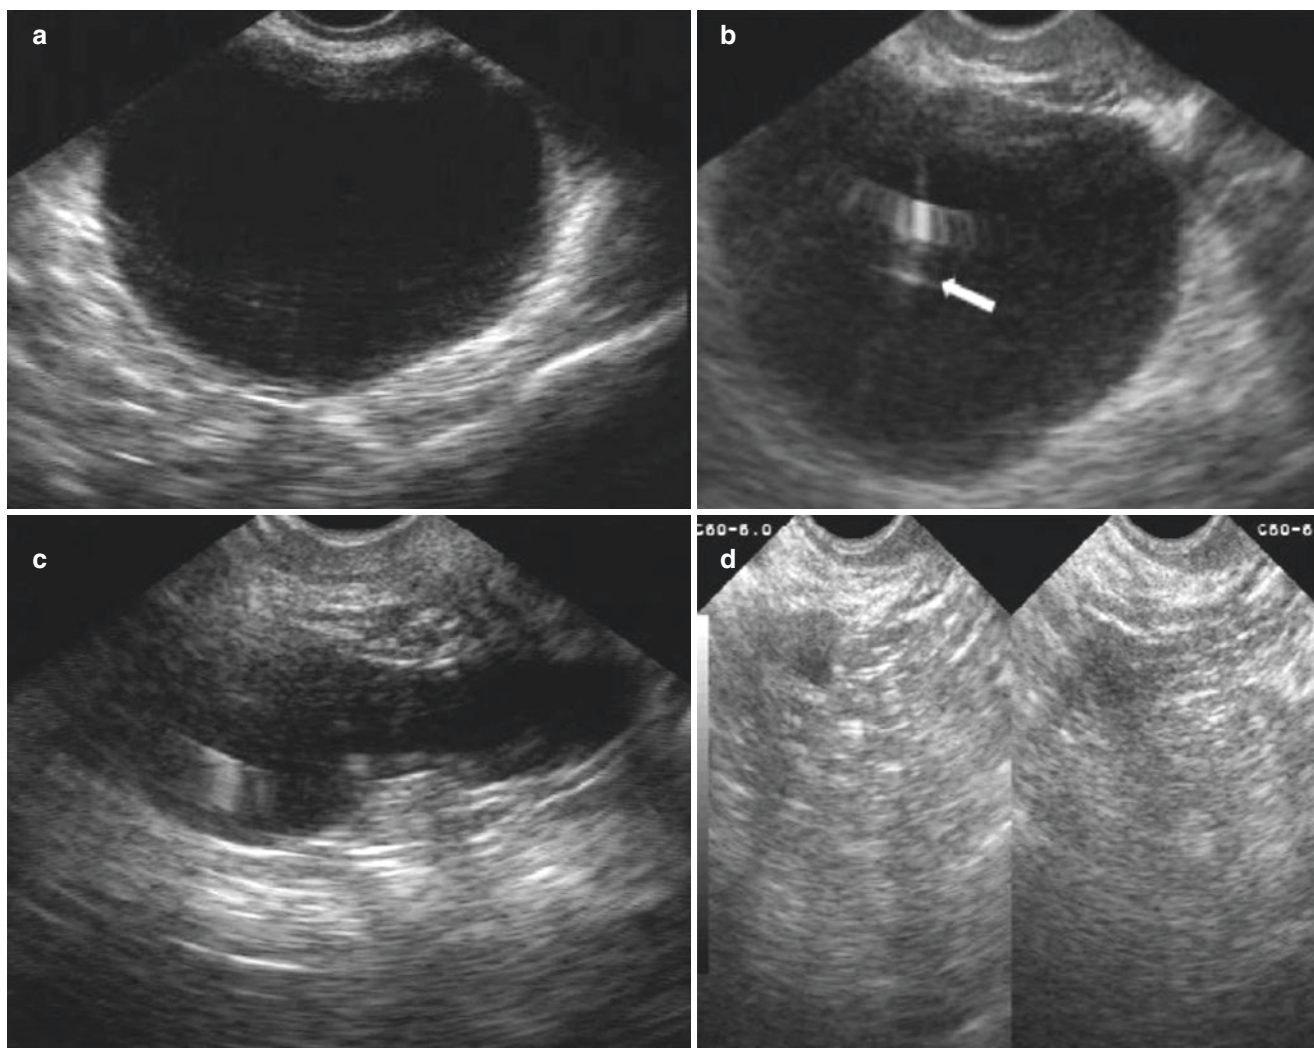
Puncture, extraction, and medicine injection of the pelvic cystic mass. (a) The patient is 45 years old, with chief complaint of hysterectomy for 1 year and adnexal cyst for four months. Preoperative transvaginal ultrasound shows a cystic mass of 9.1 cm × 8.5 cm × 7.9 cm
